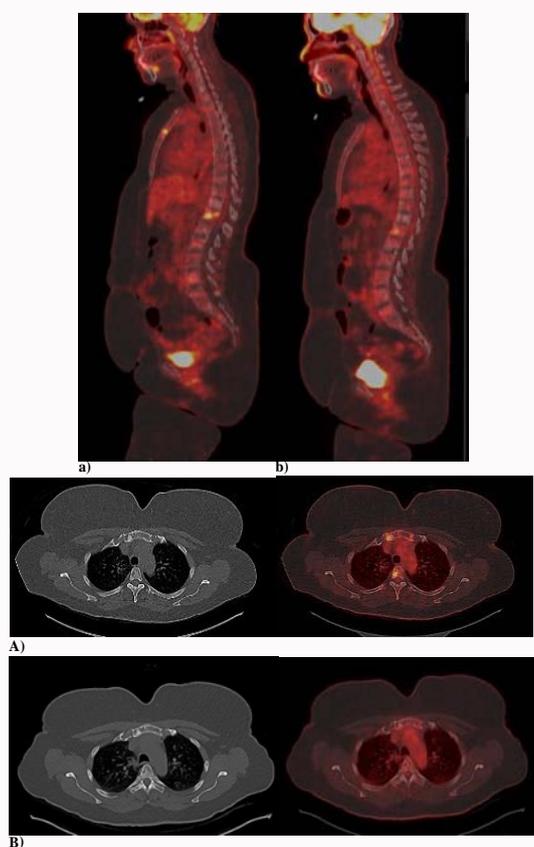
52-year female with metastatic breast cancer. PET/CT images obtained at baseline (a) and after treatment (b); shows multiple FDG avid osteolytic bone metastases on baseline which on follow up shows stable disease with RECIST 1.1 and Partial Metabolic response with PERCIST 1.0.
